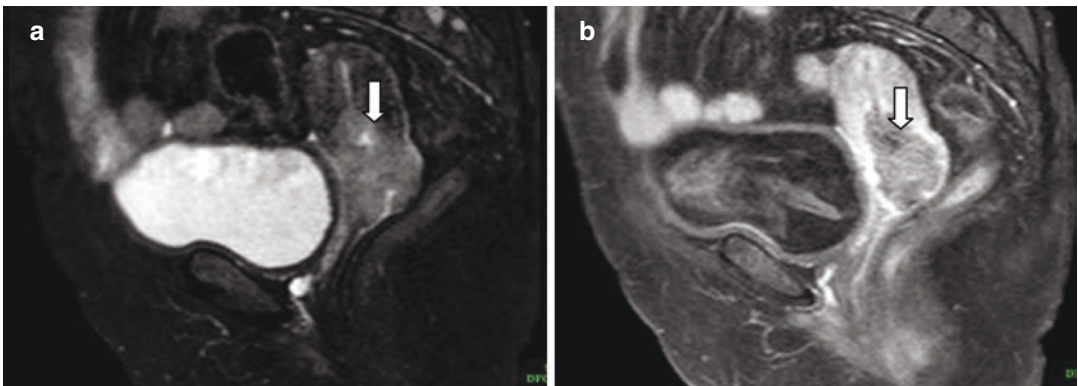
Cervical cancer. (a) Sagittal T2W MRI of pelvis showing an irregular mass (vertical arrow) in the cervix extending to lower uterine body and upper vagina. (b) On contrast enhanced image the mass is clearly seen (vertical arrow)
